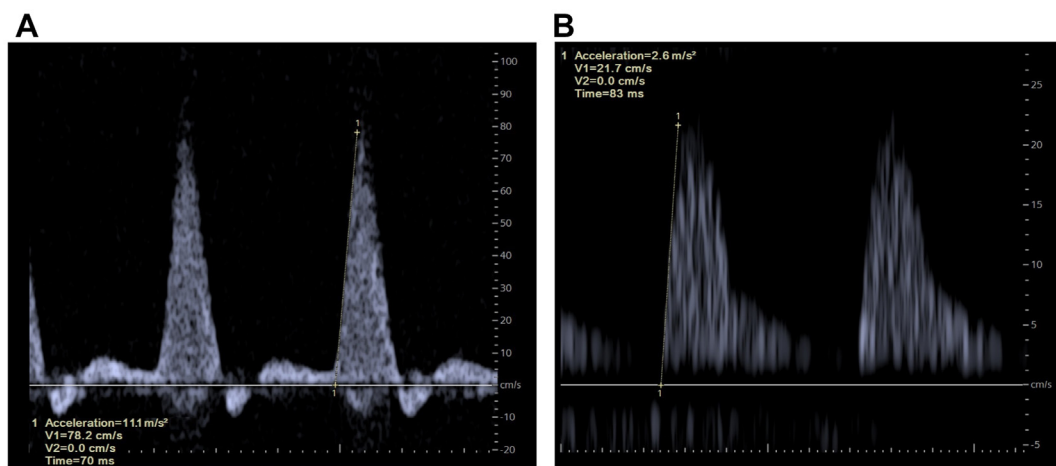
Doppler ultrasound examination. (A) Normal triphasic waveform showing a maximal systolic acceleration (ACC_{max}) measurement of 11.1 m/s^2 , calculated at the maximal slope in the systolic phase of an arterial flow (tangent line indicated by 1). (B) Abnormal waveform showing an ACC_{max} measurement of 2.6 m/s^2 , calculated at the maximal slope in the systolic phase of an arterial flow (tangent line indicated by 1). Note the differences in scales between the figures.
